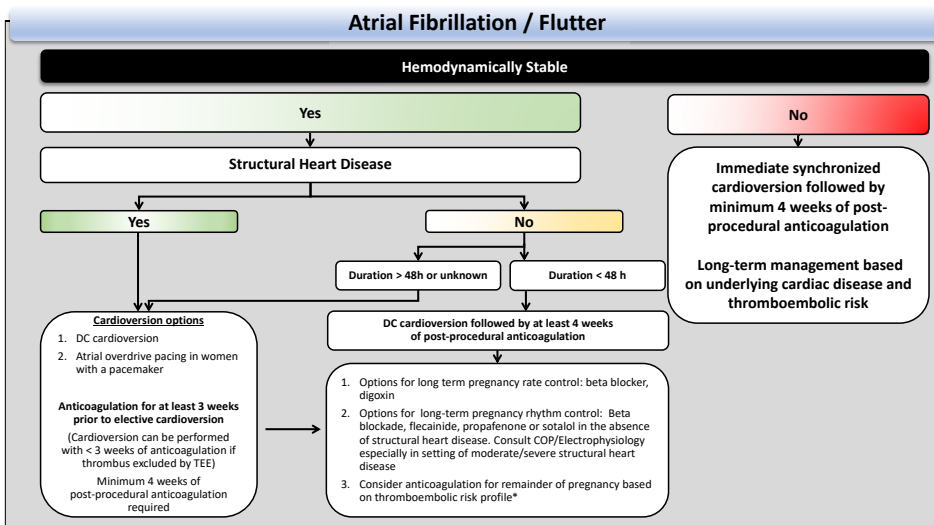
Management of atrial fibrillation/flutter during pregnancy. *Anticoagulation should be initiated in the presence of structural heart disease and/or CHADS₂ risk score ≥ 1 . COP, cardio-obstetric program; TEE, transesophageal echocardiography.
